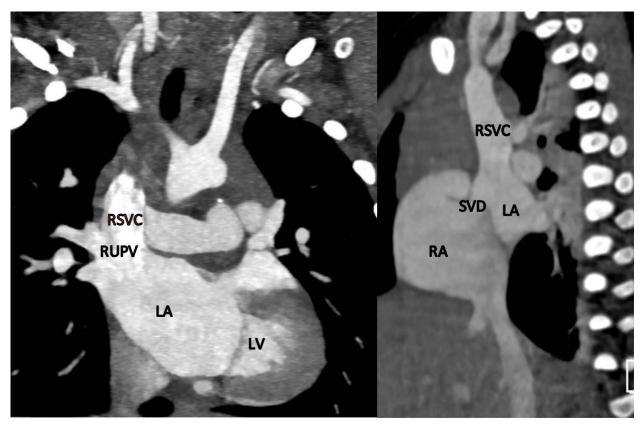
CT scan demonstrating a sinus venosus defect (SVD) with partial anomalous pulmonary venous drainage of the right upper lobe pulmonary veins (RUPV) to the right superior vena cava (RSVC), which itself inserts anomalously into the left atrium (LA)
